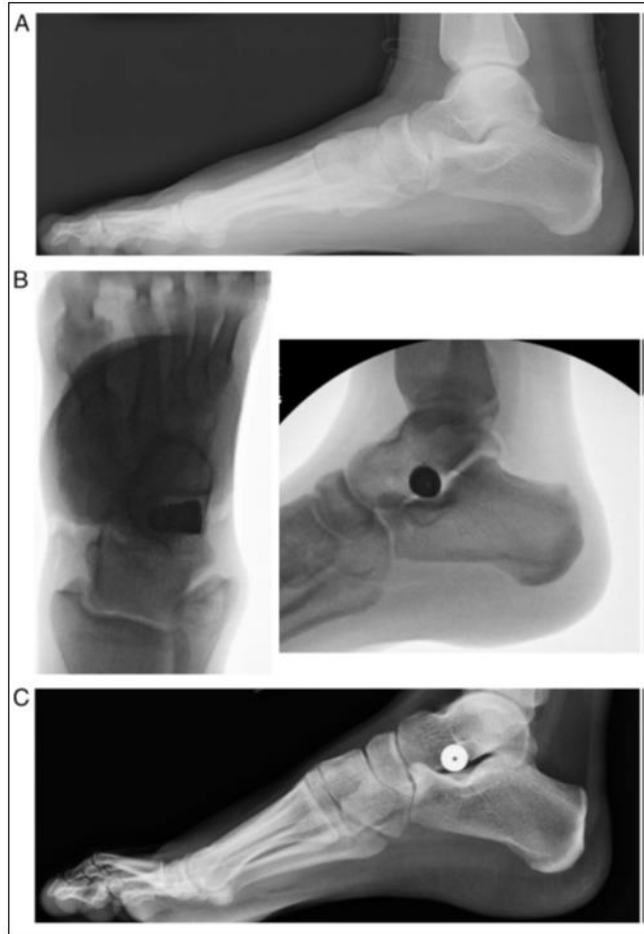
A: Preoperative horizontal radiograph of a young adult patient with serious right flatfoot. B: Intraoperative fluoroscopic radiograph after inclusion of arthroereisis case, anteroposterior and horizontal. C: Postoperative horizontal radiograph uncovering stable situation of arthroereisis and improved average foot curve [60].
